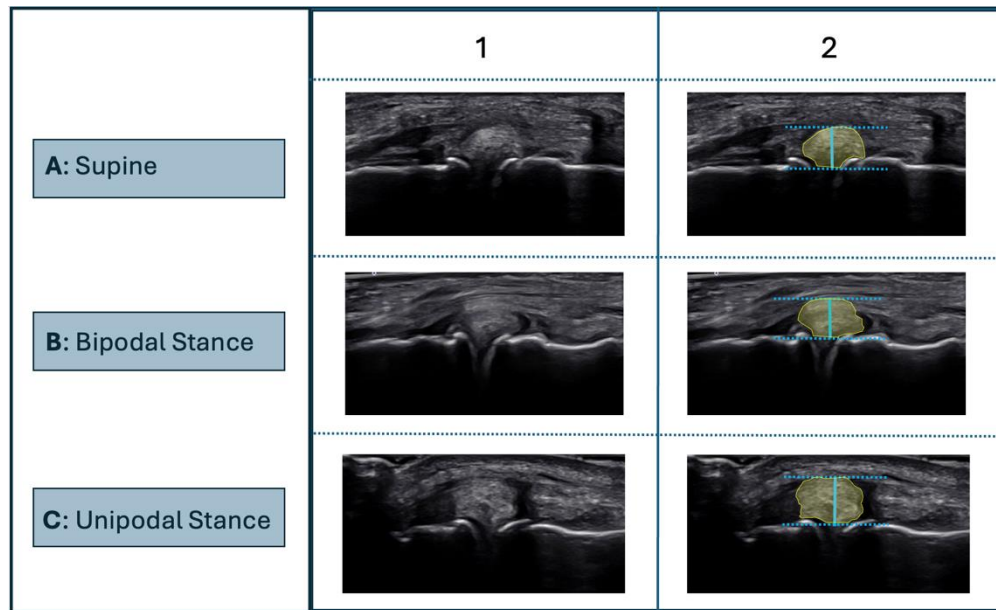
Ultrasound is used to measure extrusion CSA (yellow) and extrusion distance (blue) in 3 different weight-bearing positions
